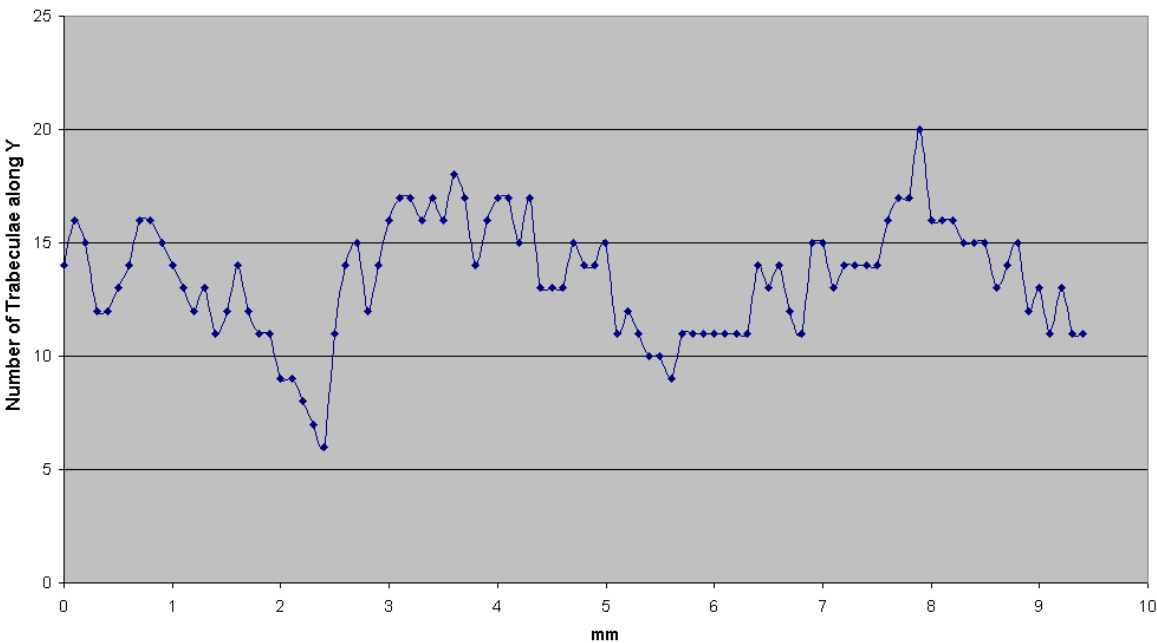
Cubic  $\mu$ CT sample: number of trabeculae along Y
